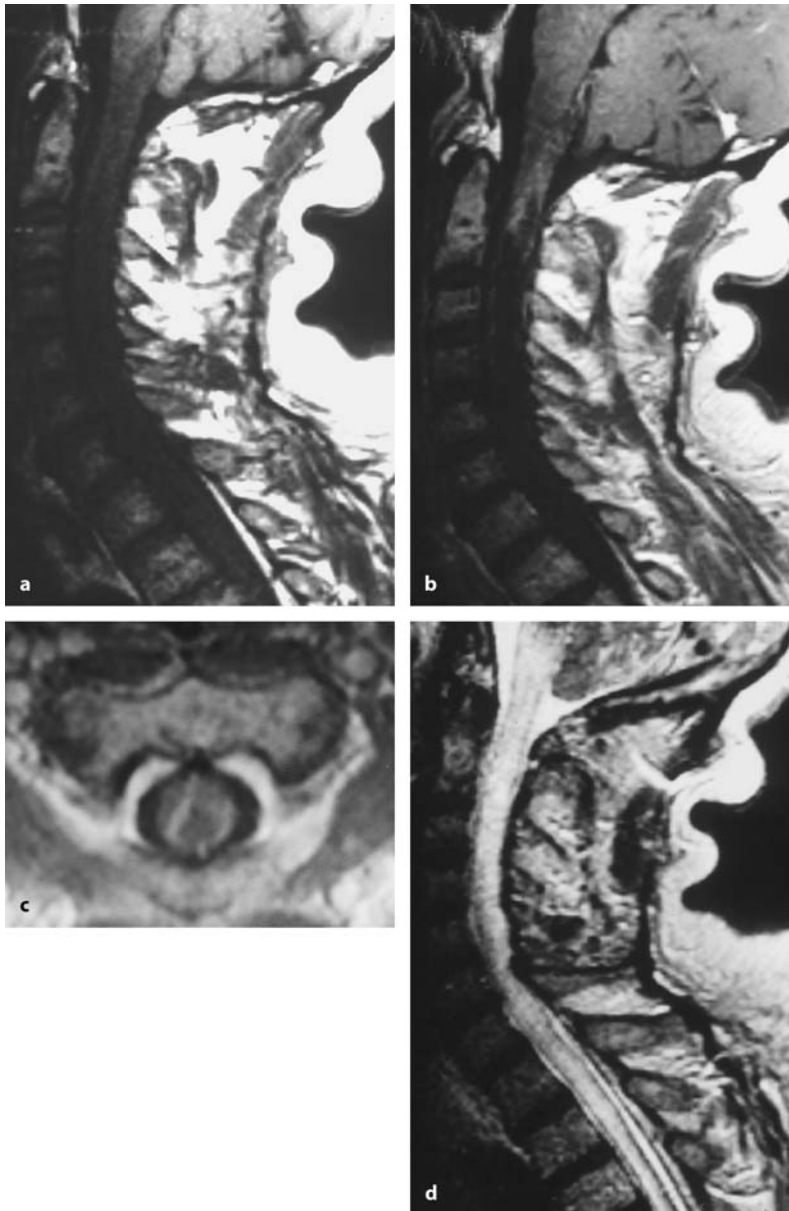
Sagittal, contrast-enhanced T1-weighted image (a) and T2-weighted image (b) of a lesion at C3–C4. These images could easily be misinterpreted as a contrast-enhancing intramedullary tumor. However, a space-occupying effect is again missing. Coronal (c) and axial (d) T2 images demonstrate bilateral lesions. The patient was diagnosed with non-Hodgkin's lymphoma
